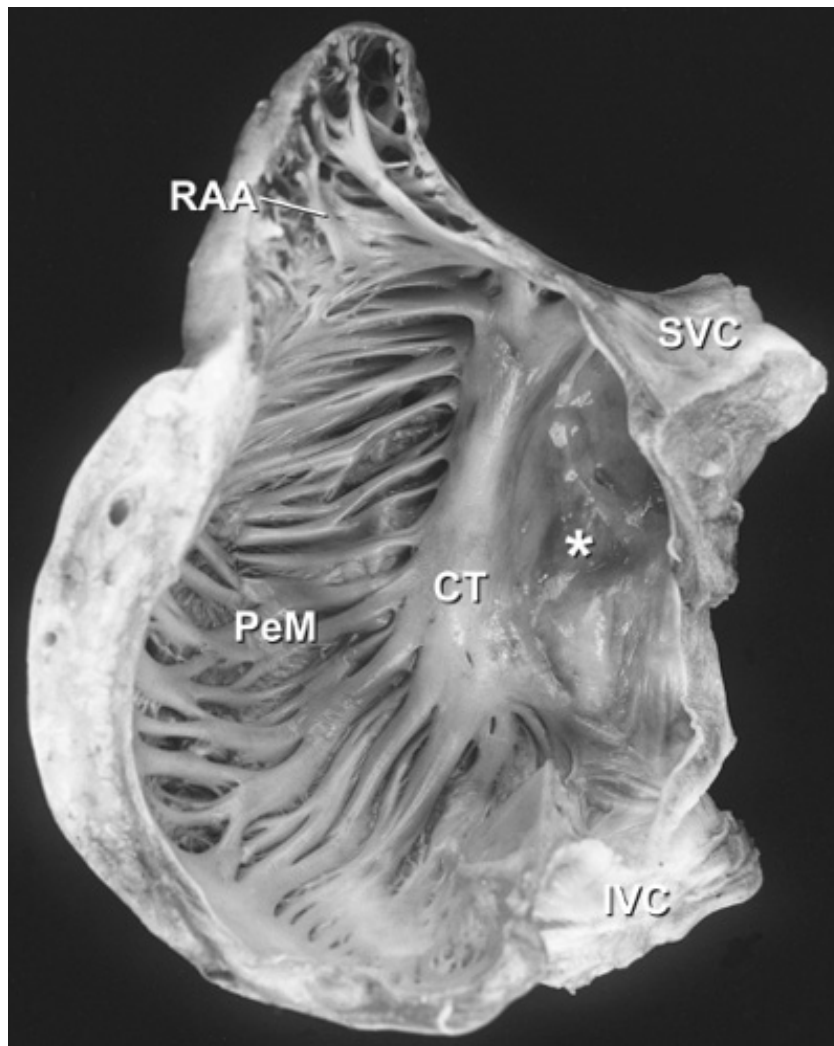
Right atrial free wall showing separation of the posterior smooth-walled (*) portion from the anterior muscular portion with its pectinate muscles (PeM) and right atrial appendage (RAA) by the crista terminalis (CT). IVC, inferior vena cava; SVC, superior vena cava.
